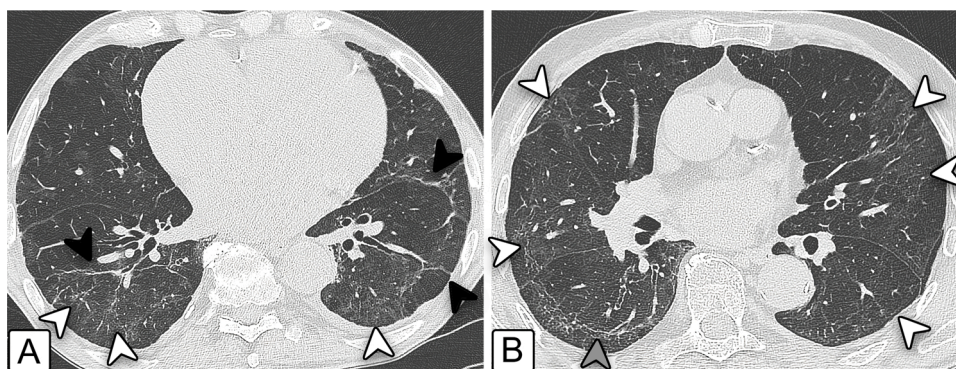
Images from unenhanced chest CT scan of an 89-year-old man who suffered severe COVID-19. The examination was performed 96 days after the disease onset. Axial images show bilateral ground-glass opacity with superimposed reticulation (white arrowheads, A and B), parenchymal bands (black arrowheads, A) and subpleural curvilinear opacities (gray arrowhead, B).
